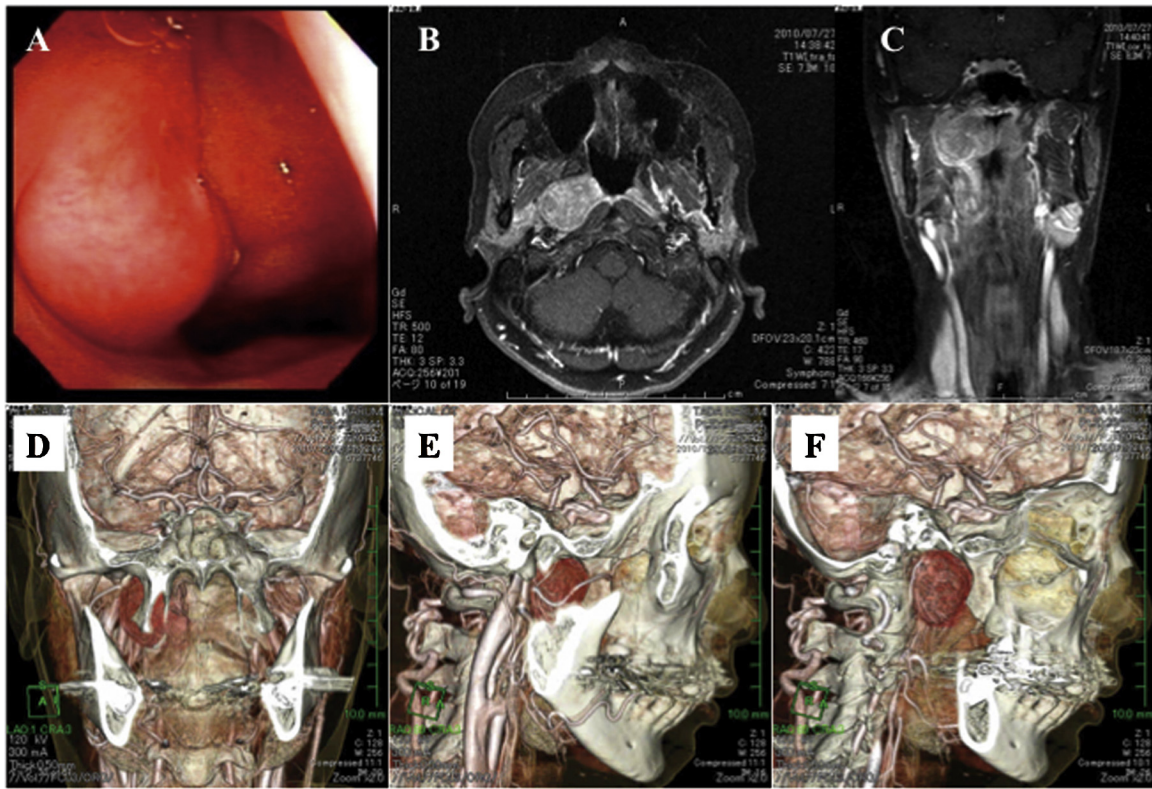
(A) Endoscopic view of the primary tumor. (B, C) Horizontal and coronal magnetic resonance images with enhancement. (D–F) Three-dimensional computed tomography images.
